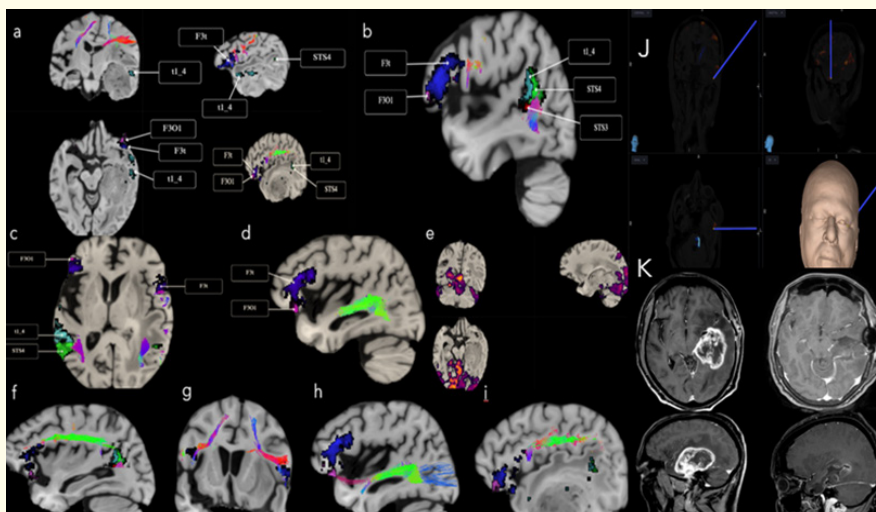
a,b,c,shows parcellations of language areas at frontal and temporal areas , d - optic radiation above temporal horn, e- visual network , f- arcuate fasciculus, g- Fronto aslant tract, h- IFOF, J- neuronavigation integration for selecting transulcal approach away from parcellations. K- pre and post operative MRI showing gross total excision.
